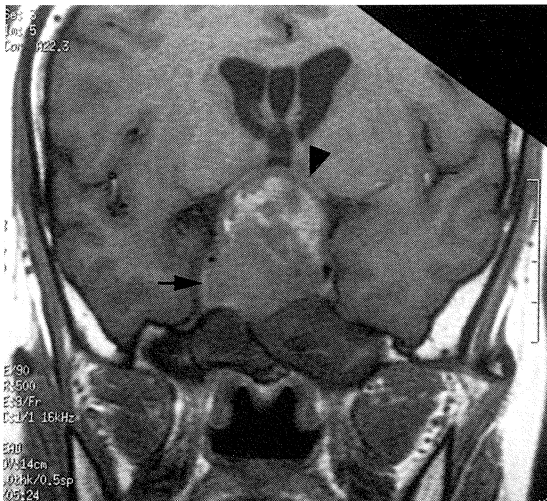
Coronal SE T1-W MR image of the brain, at the level of the pituitary fossa.
